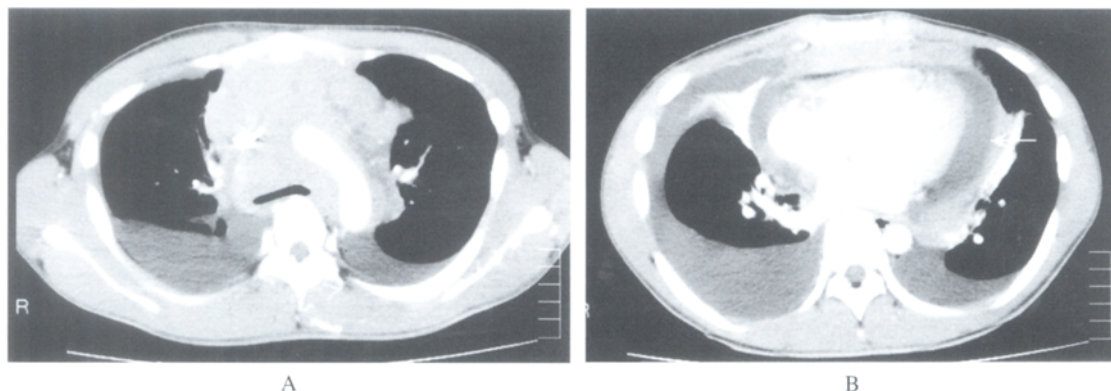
Computed tomography study showed that the normal mediastinal structures were clearly displaced by the huge mediastinal mass. Bilateral massive pleural effusion and pericardial effusion were noted.
